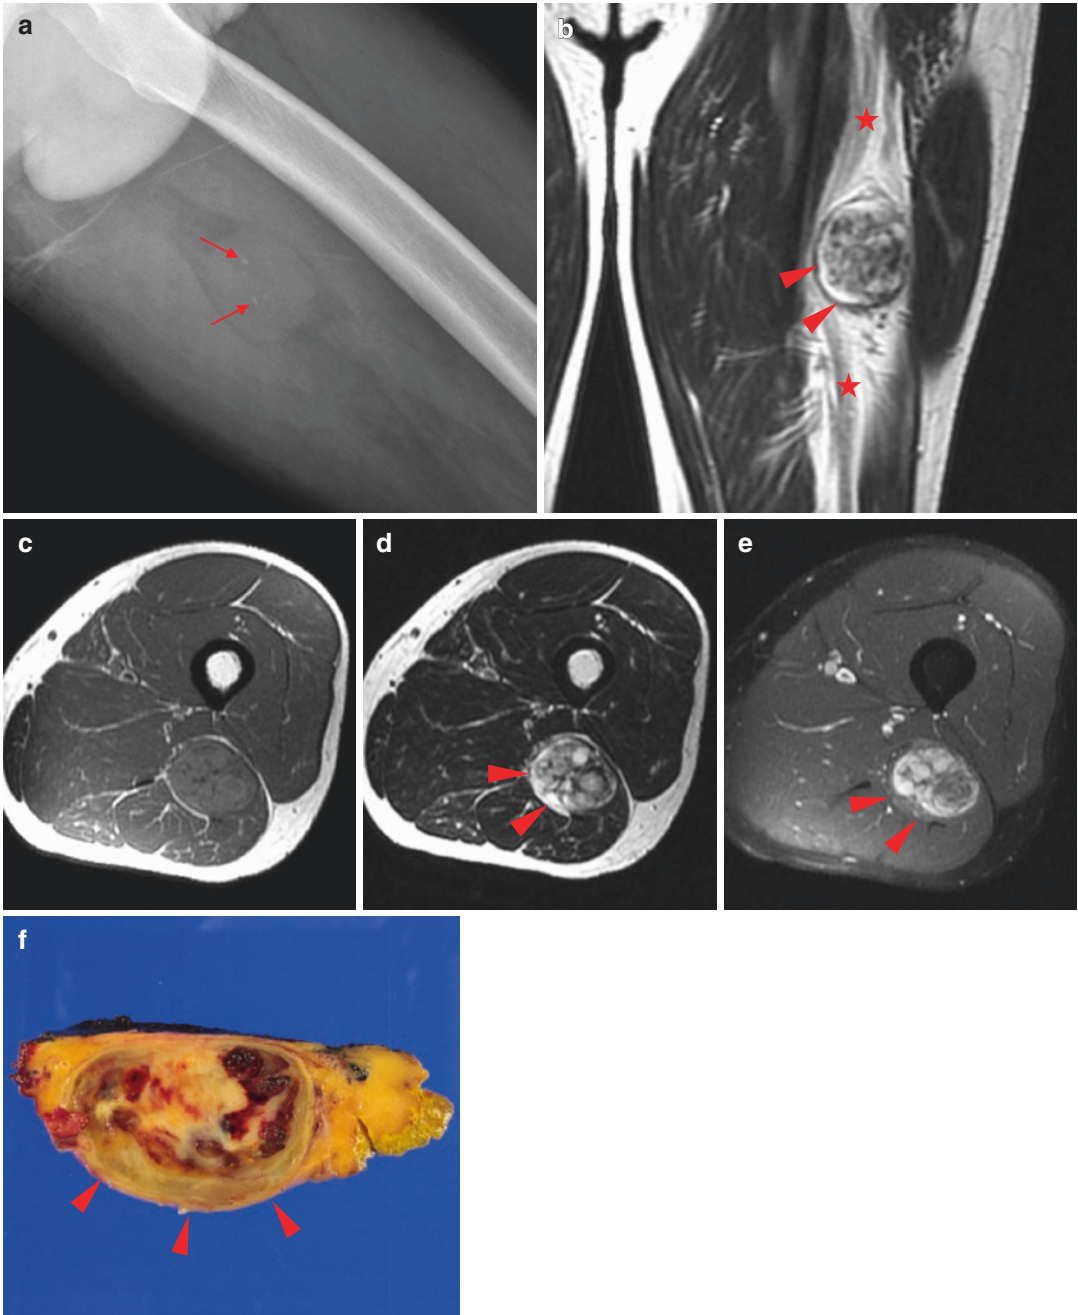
Ancient schwannoma. Radiograph of the thigh (a) shows a circumscribed soft tissue mass with internal spotty calcifications (*small arrows*). The tumor is eccentrically located along the sciatic nerve (*stars*), with prominent peritumoral fat overgrowth on coronal T2WI (b). The lesion is inhomogeneously hyperintense to muscle on T1WI (c) and mixed signal on T2WI (d). Heterogeneous
